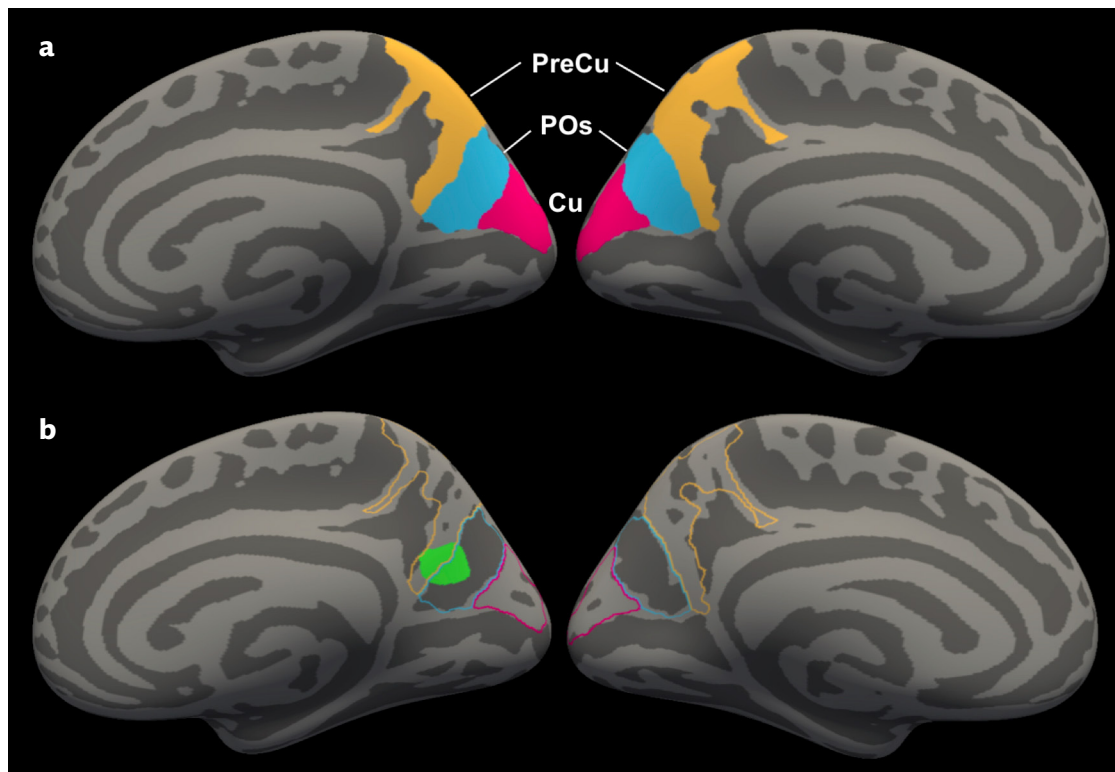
a) Representation of regions defined as a region of interest for CT analysis performed in a restricted area according to VRS results. Pink: cuneus (Cu), blue: parieto-occipital sulcus (POs), and yellow: precuneus (PreCu). b) Representation of the cluster showing cortical thinning at the junction of POs and PreCu at the right hemisphere (in green).
